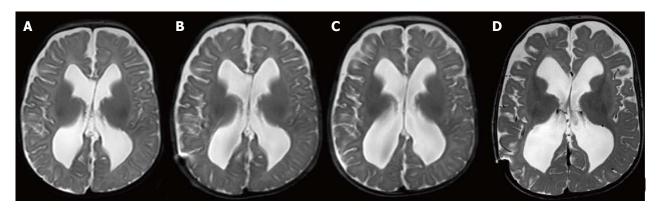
T-2 weighted magnetic resonance imaging demonstrating shunt failure and progression of hydrocephalous over the course of 4 mo of treatment. A: Pre-shunting axial T-2 weighted MRI ordered after patient had increased head circumference and suture splaying demonstrating ventriculomegaly; B, C: Subtle increase in ventricular size at 2 wk (B) and 6 wk post-shunting (C); D: At 4 mo post-operative shunting with significant increase in ventriculomegaly and extra axial fluid spacing. MRI: Magnetic resonance imaging.
